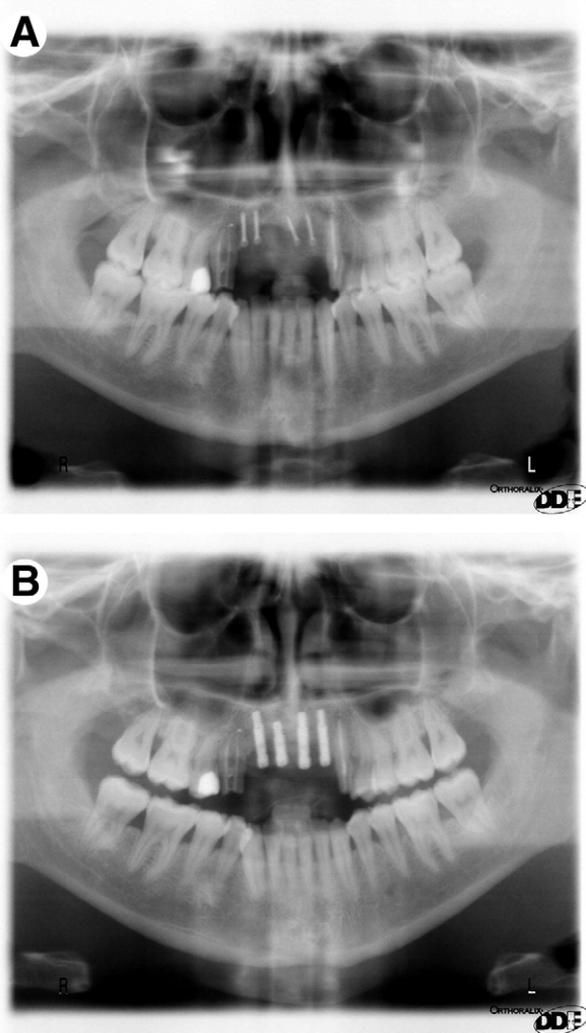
Panoramic radiographs 5 months after augmentation (A) and 6 months after placement (B).
